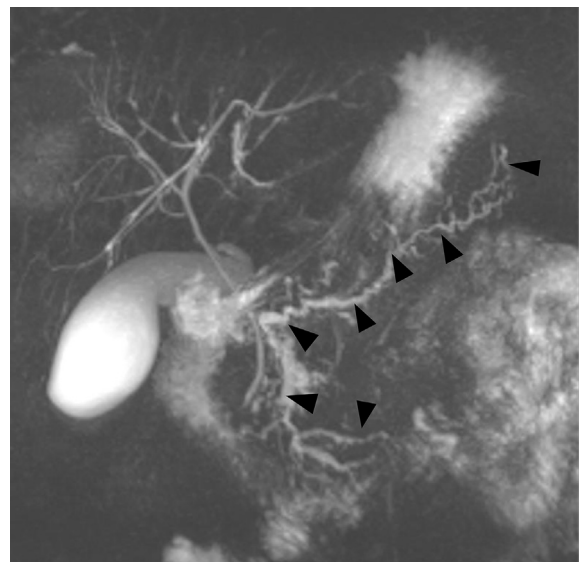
Heavily T2-weighted thick-slab MRCP shows normal biliary ductal system and gallbladder. The entire pancreatic ductal system (marked by arrowheads) is beaded with segments of dilatation (main and side branches) and strictures. Together with the relatively low signal-intensity in the pancreatic parenchyma on fat-suppressed T1-weighted image (not shown), findings are consistent with chronic pancreatitis.
